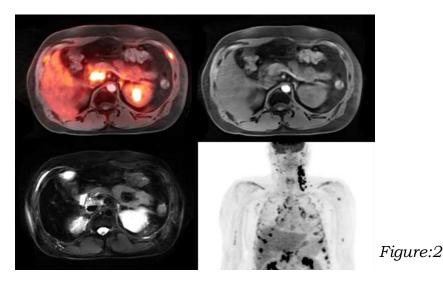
48 year old male with recurrent T-cell lymphoma. PET-MRI demonstrates a small cluster of hyper metabolic lymph nodes in the precaval region of the upper abdomen (top left). The lymph nodes are mildly hypo intense on T1 radial VIBE (top right) and hyper intense on T2 blade with fat suppression (bottom left). PET MIP image shows multiple hyper metabolic left neck lymph nodes in addition to the upper abdominal lymph nodes. There is bone marrow involvement that is best seen within the ribs (bottom right).
